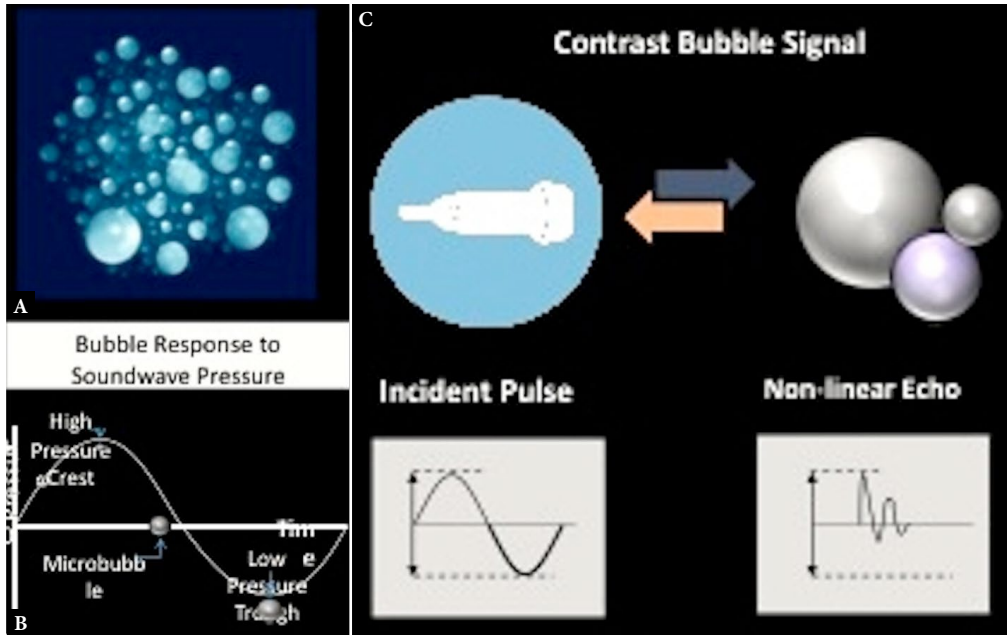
Contrast agents. A. Microbubbles made up of a gas core with a flexible, biocompatible containment shell which is usually phospholipid but can also be a protein, such as albumin. Bubble size typically varies between 2–10 microns. B. The insonating beam operates at the resonant frequency, which is dependent on bubble size. Microbubbles in the ultrasound field react to pressure by changing size, based on the pressure amplitude of the insonating beam as indicated. C. The resultant scattered echoes are non-linear, which can be represented as an expansion consisting of the fundamental along with higher harmonic components. The goal of contrast imaging is to remove the fundamental component (e.g. tissue contribution) and image the second harmonic. Images printed with permission of Siemens medical systems
